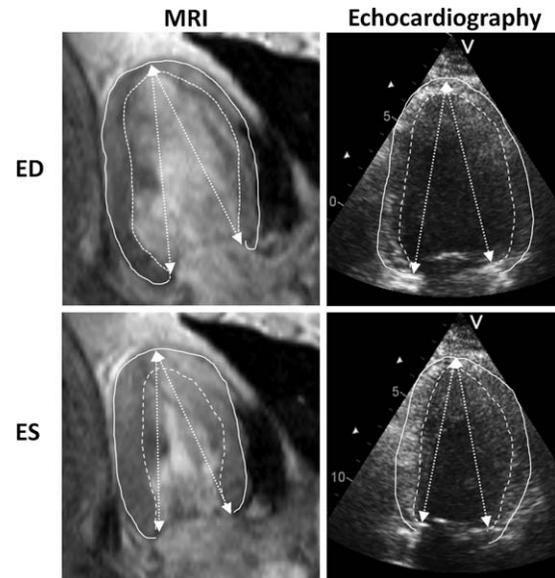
MRI (left) and echocardiographic (right) images from a representative participant during end diastole (ED, top) and end systole (ES, bottom). Measurements of LV length from the epicardium of the apex to the mitral valve insertions are displayed with arrows. Epicardium (solid line) and endocardium (dotted line) are delineated. In this patient, LAS was 9.6% by MRI and 10.2% by echocardiography.
